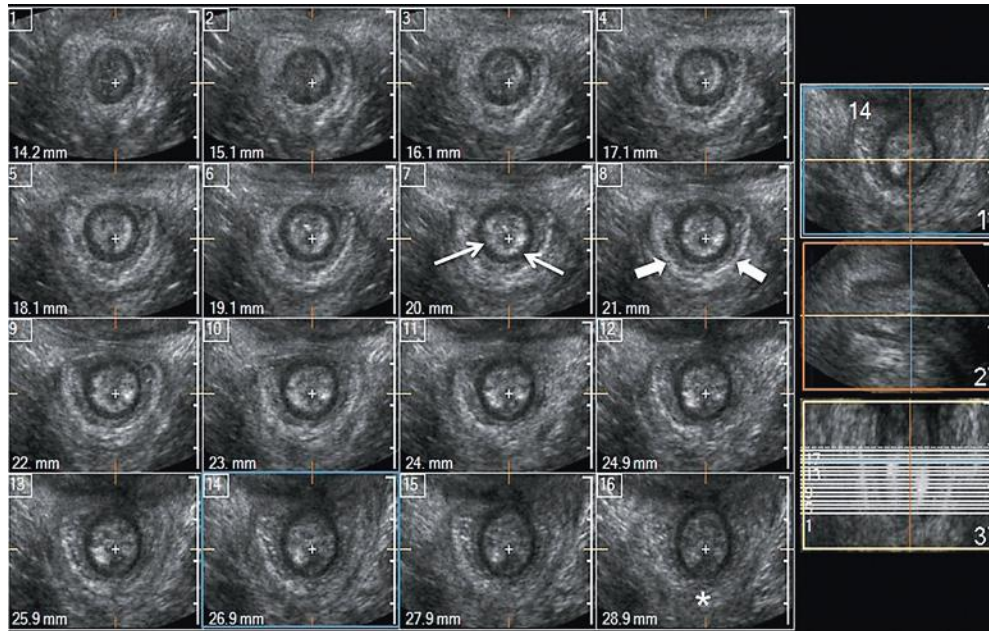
Multiplanar three-dimensional transperineal ultrasound image of the anal canal. Multiple axial images of the anal canal depicting the cross section of the anal canal structures from the caudal (1) to the cranial (16) sections. The cranial images show absence of the anterior portion of the external anal sphincter at the level where the puborectalis muscle sling (*asterisk*) is normally visualized behind the anal canal (*asterisk*). The internal anal sphincter (*thin arrows*) and external anal sphincter (*thick arrows*) are well visualized on the crosshair at the midlevel of the anal canal.
